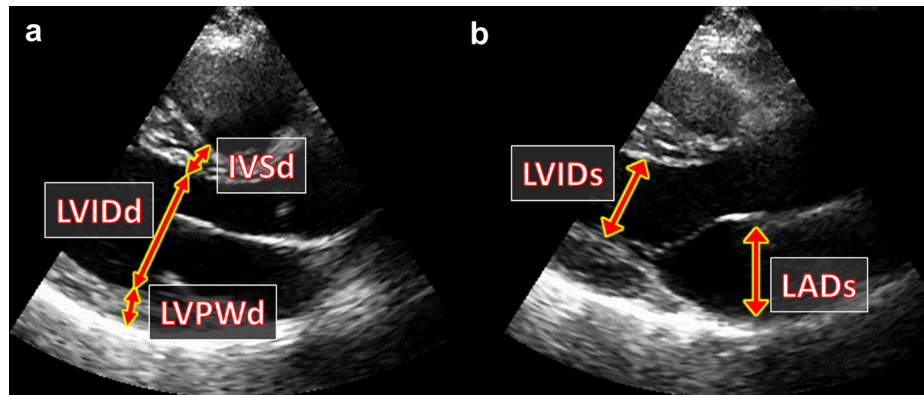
(a) Example measurements of the interventricular septum thickness (IVSd), left ventricular internal dimension (LVIDd) and left ventricular posterior wall (LVPWd) during end diastole (ED). (b) Example measurements of left ventricular internal dimension (LVIDs) and left atrial dimension (LADs) during end systole (ES). All measurements were made across the parasternal long-axis view of the heart.
